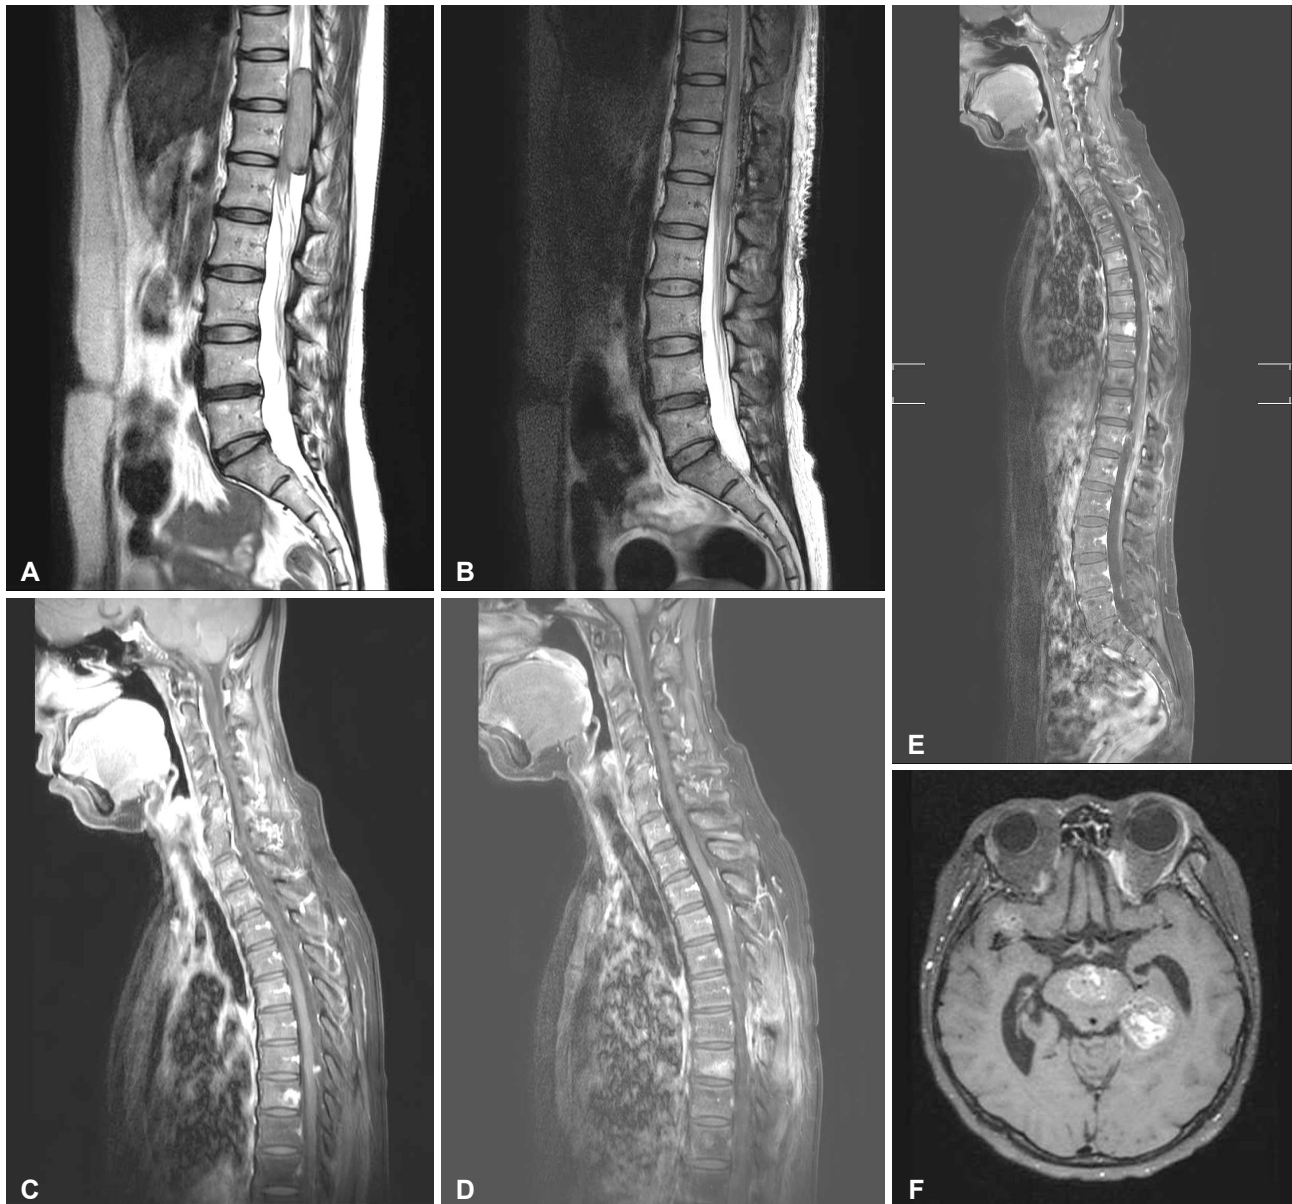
Serial MRI findings. A: Preoperative T2-weighted image obtained in March 2020. B: Postoperative T2-weighted image obtained in March 2020. C: Contrast-enhanced T1-weighted image showing focal leptomeningeal metastasis in the T7 area obtained in August 2021. D: Contrast-enhanced T1-weighted image showing focal leptomeningeal metastasis in the T3 and fourth areas obtained in January 2022. E: Contrast-enhanced T1-weighted image showing diffuse leptomeningeal metastases obtained in January 2023. F: Contrast-enhanced T1-weighted image showing brain metastases obtained in July 2023.
